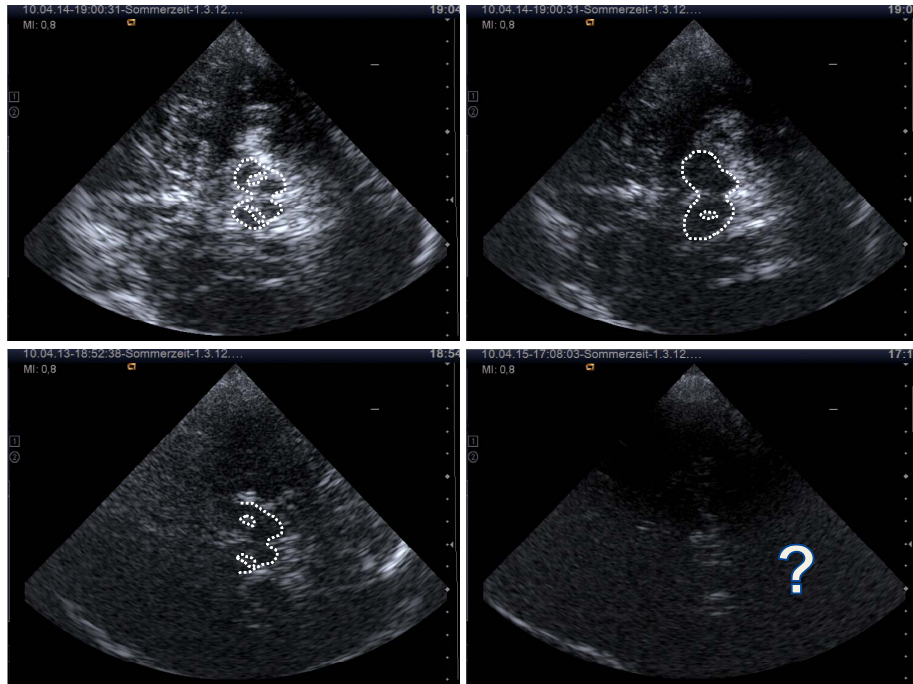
Four examples of transcranial ultrasound (TCUS) images in 2D. The midbrain and substantia-nigra hyper-echogenicities within the midbrain are highlighted with a white dashed outline. Top left: the example shows a TCUS image quality given an optimal bone window, leading to comparably high contrast and complete anatomic outlines of midbrain and SN. Top right: the image was taken through a medium-quality bone window with lower contrast and less visible anatomy surrounding the midbrain. Bottom left: the image shows a low-quality situation, with partly missing midbrain boundaries, low contrast, few visible anatomic features and low contrast of the opposite cranial wall. Bottom right: in about 10% of subjects, the bone window does not allow sufficient sound energy to penetrate the skull [24]. This leads to un-interpretable images, both in 2D and 3D.
